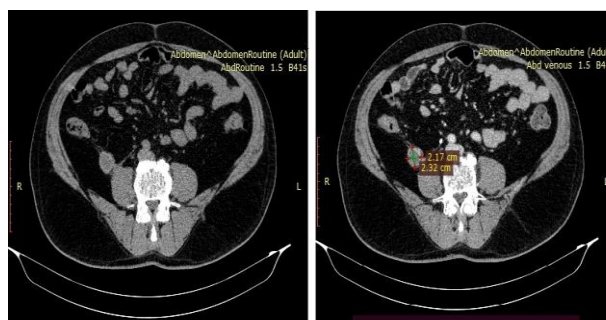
Iliopsoas haematoma - first CT (A, B, C, D) and control CT on the 7th day (E, F, G, H).
